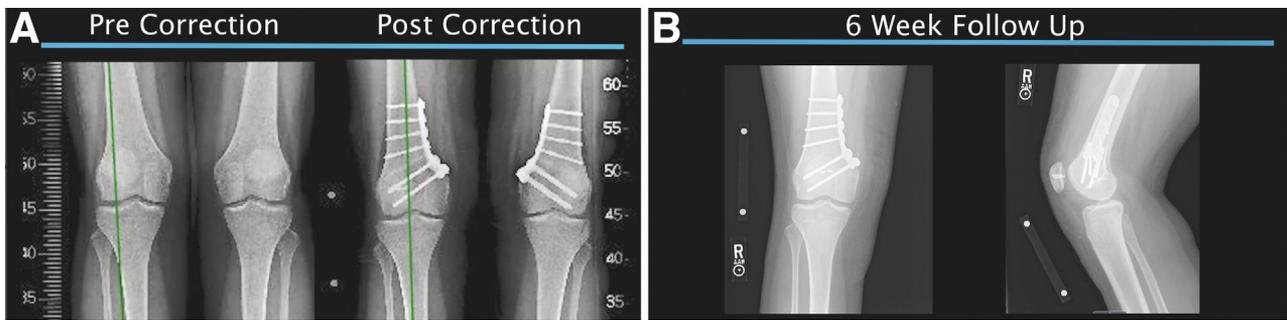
(A) Full-length alignment films are shown zoomed in at the knee joint, comparing precorrection to postcorrection of the right leg. (B) Anteroposterior and lateral radiograph imaging is shown taken at 6 weeks follow-up of the right knee.
